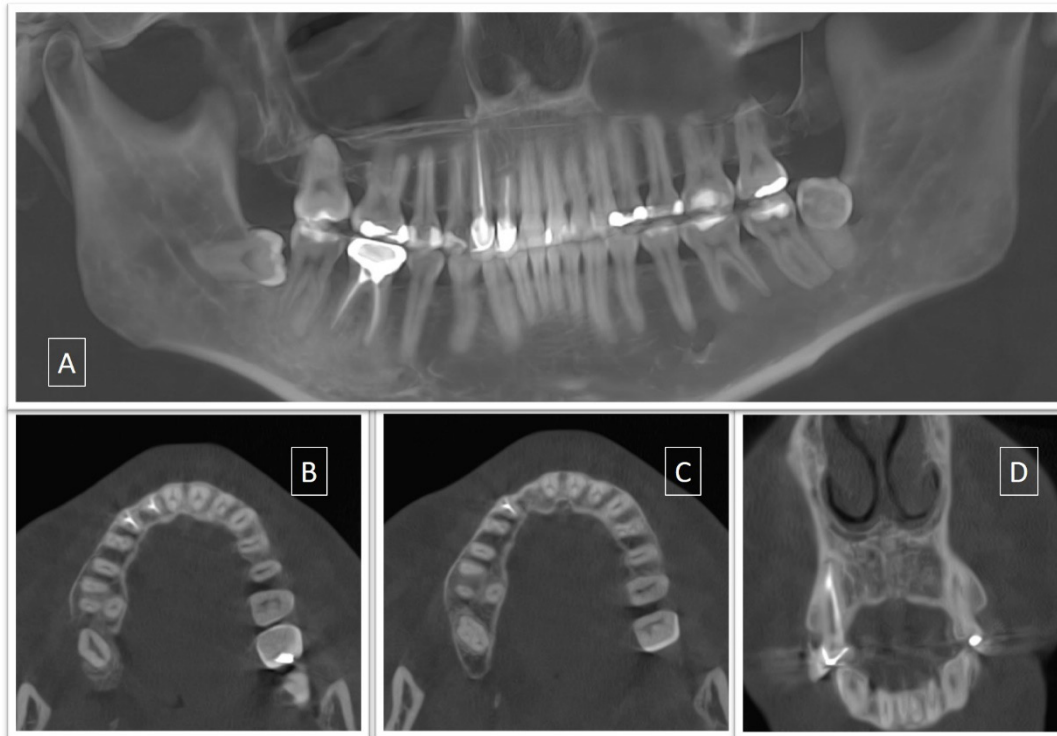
A. Panoramic radiograph at 8-year follow-up visit. B.C.D. CBCT scan views (axial and coronal) at 8-year follow-up showing healing and no recurrence
